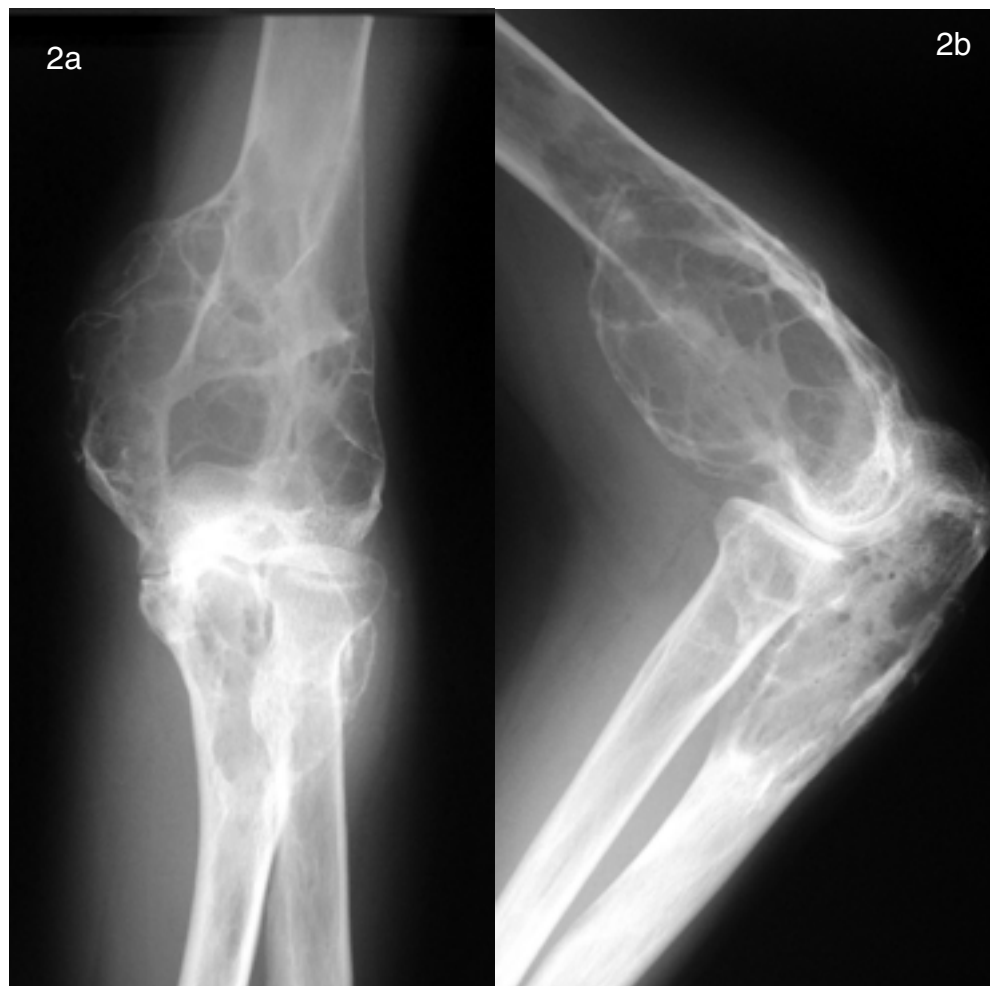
Plain radiographs of the left elbow. Radiographs showed a ground glass appearance and marginal sclerosis. (a: anterior view; b: lateral view)
